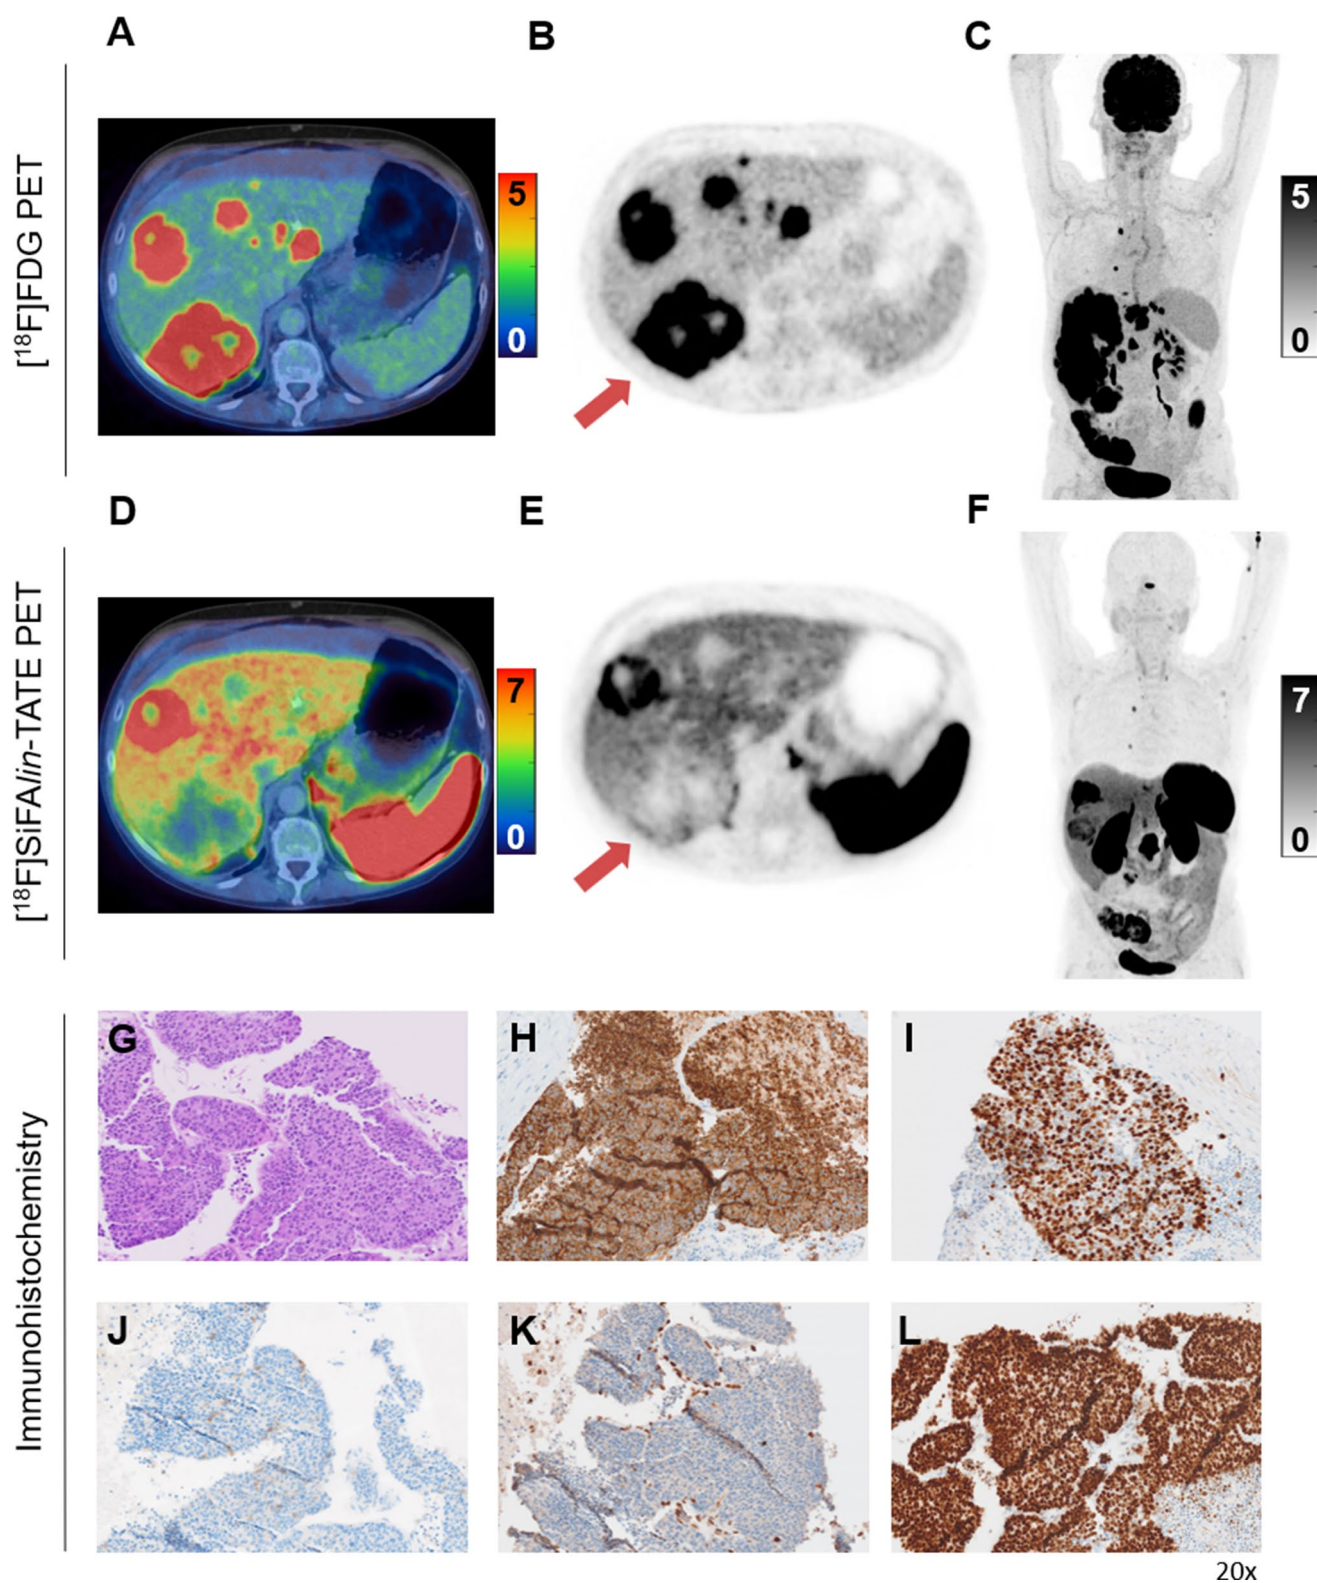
Axial PET images and maximum intensity projections of low activity $[^{18}\text{F}]\text{FDG}$ PET (27 MBq) (A-C) followed six hours later by a standard activity $[^{18}\text{F}]\text{SiFalin-TATE}$ PET (167 MBq) (D-F). In this 65-year-old female patient initially diagnosed with a G3 colon NET, a dual-tracer PET/CT was conducted following indications of progressive disease. To further evaluate tumor aggressiveness, a PET-targeted
